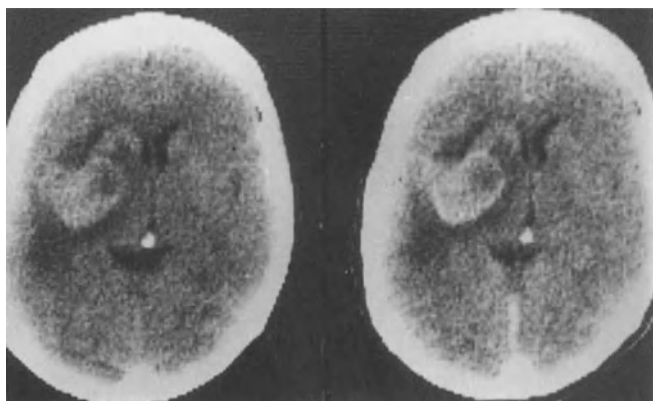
This CT scan shows a giant middle cerebral artery aneurysm extending into the basal ganglia
